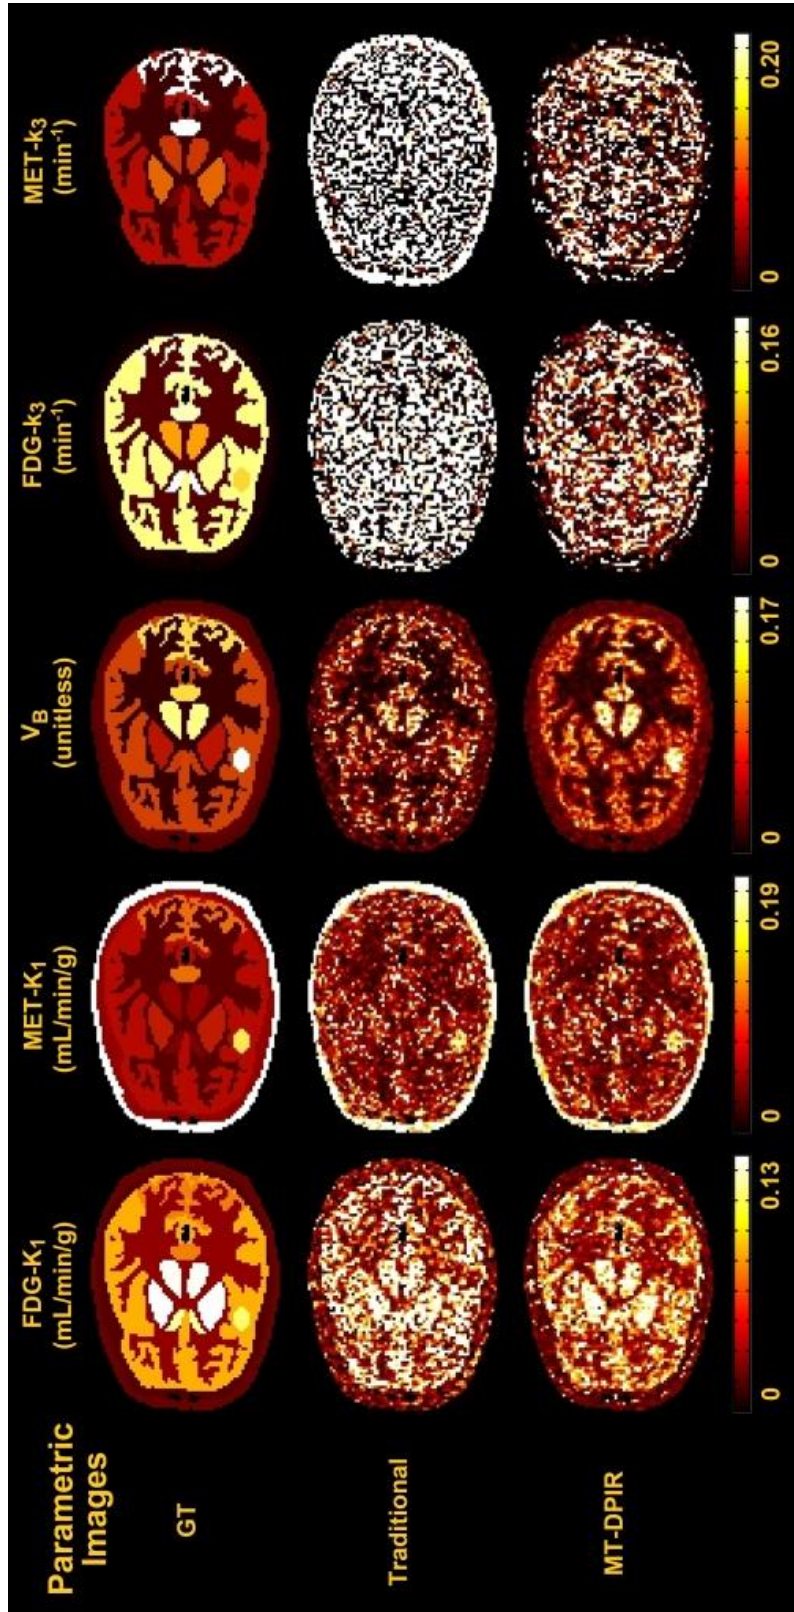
Sample parametric images of FDG and MET tracers from a randomly selected dataset, obtained from the traditional method (192 iterations) and MT-DPIR (240 iterations) (The maximum value of color bars are set to be the maximum value of \mathbf{p} 's as listed in Tab. 3.1.)
